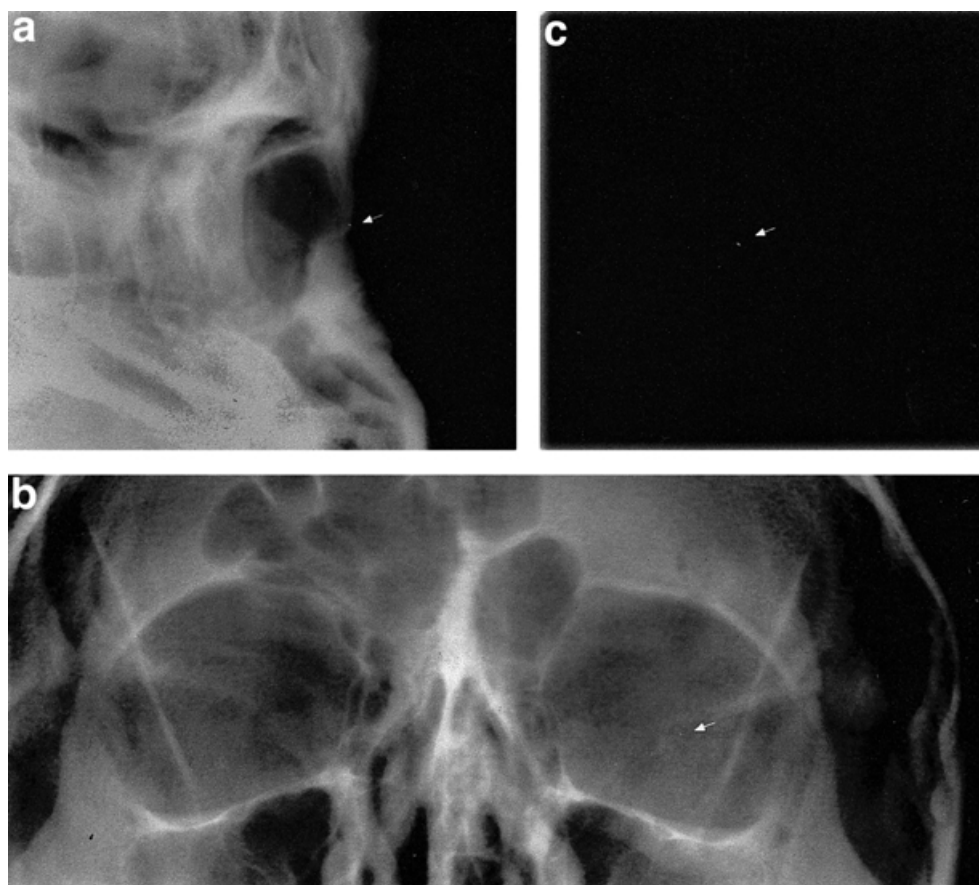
(a,b) Preoperative X-ray. Reported as no evidence of intraocular foreign body; however, closer inspection does show evidence of a metallic intraocular foreign body (→). (c) The radiological appearance is better appreciated when the intraocular foreign body is viewed as imaged by X-ray after its removal from the eye.
